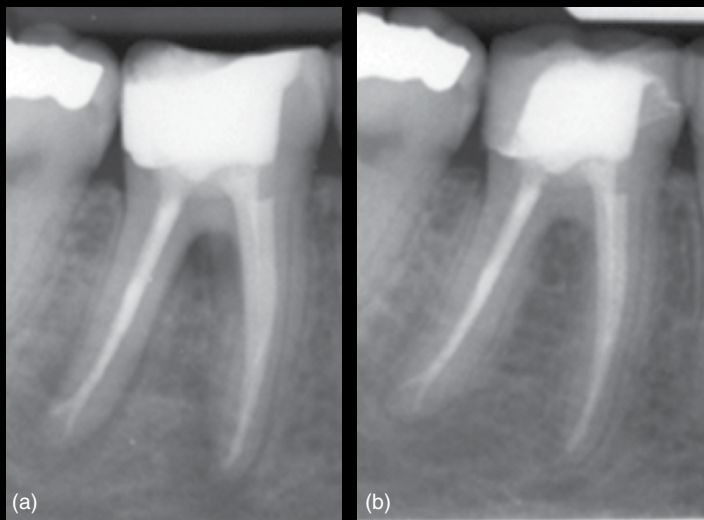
Periapical radiographs: (a) post treatment; (b) 12 months following treatment.
